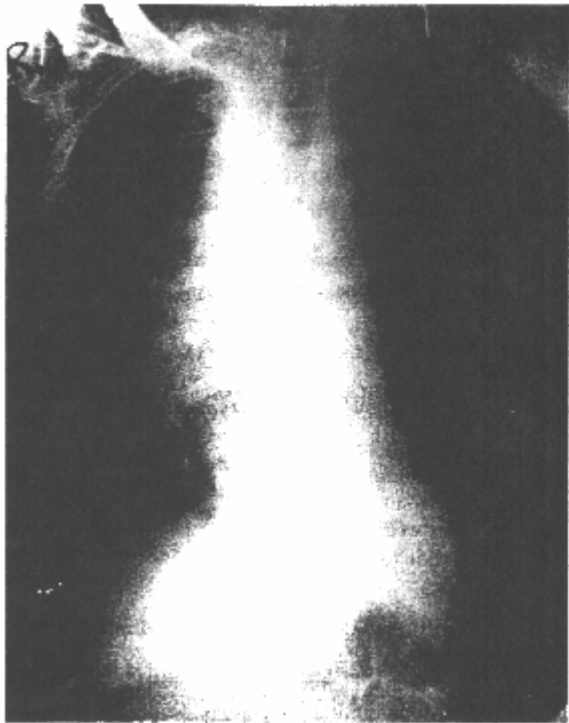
Chest roentgenogram showing a widened mediastinum due to hemorrhagic mediastinitis in a patient with a fatal case of inhalation anthrax. (Reprint with permission from [6]).
